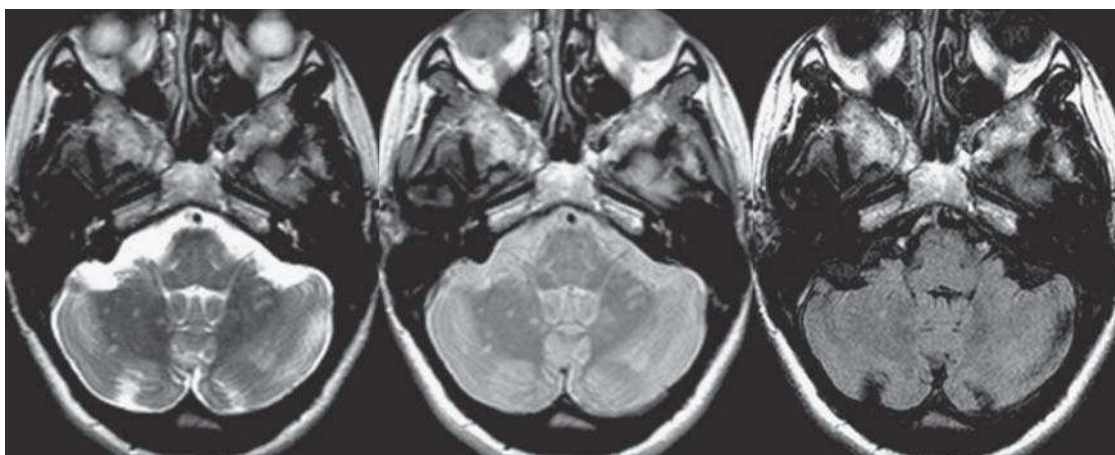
Brain magnetic resonance imaging. T2-weighted sequences (left), proton density (centre) and fast-FLAIR (right) in the transverse plane in a patient with clinically-defined multiple sclerosis. There are multiple small demyelinating lesions, many of which are not visible in the fast-FLAIR sequence.
